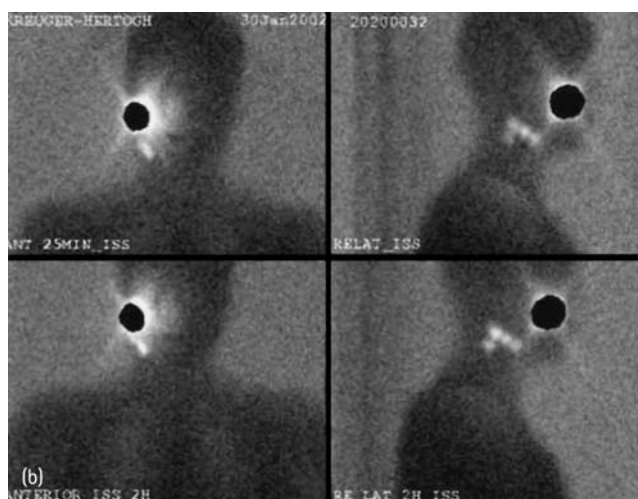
Sentinel node biopsy procedure in a female patient with a nodular melanoma of the cheek. (a) US-guided FNAC did not reveal the presence of pathological lymph nodes. On day 0 the sentinel node(s) are identified by lymphoscintigraphy. (b) After a radiotracer pharmacoin (^{99m}Tc-labelled colloidal albumin) is injected around the primary tumour, dynamic images are made using a gamma-scan. (c) The sentinel nodes are marked on the skin.
